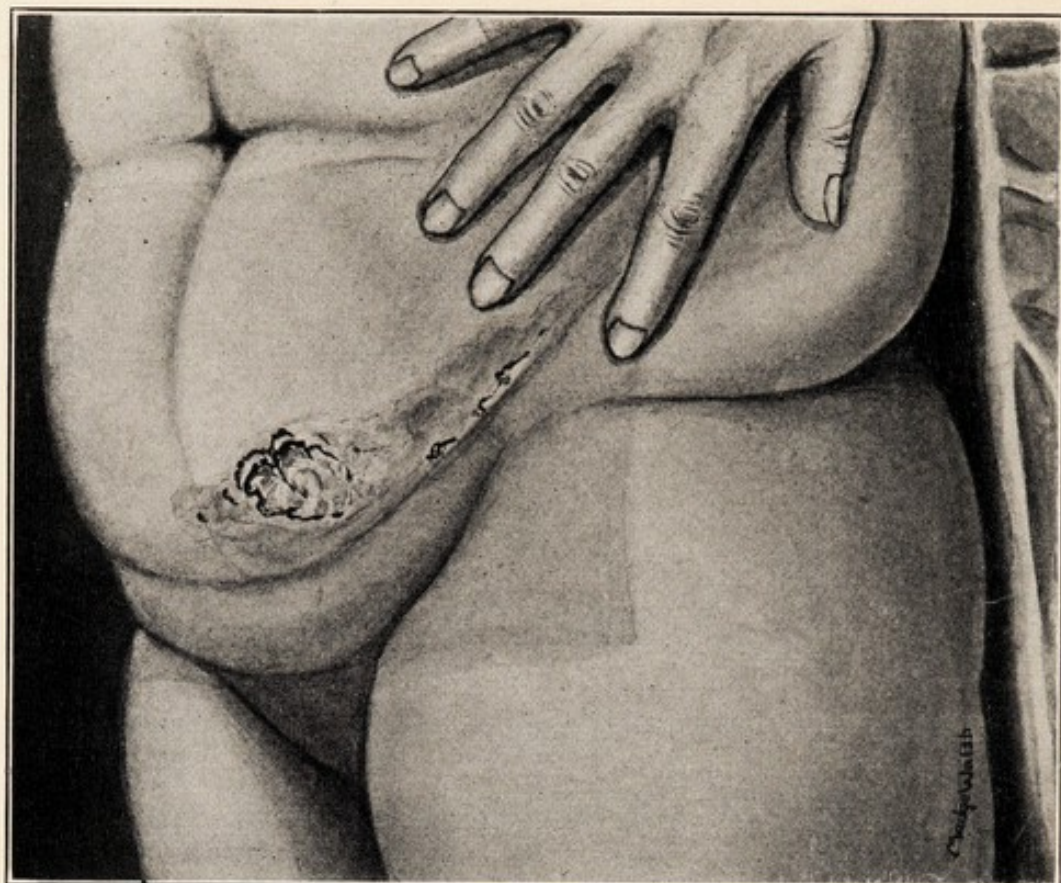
X-RAY ULCER FROM ONE APPLICATION OF A 100 PER CENT SKIN DOSE, APPEARING 18 MONTHS AFTER CESSATION OF TREATMENT AND PRESUMABLY CAUSED BY THE CHANGES IN THE SKIN OF THE LOWER TRANSVERSE FOLD DUE TO A MARKED PENDULOUS ABDOMEN AND CONTINUOUS MOISTURE.
